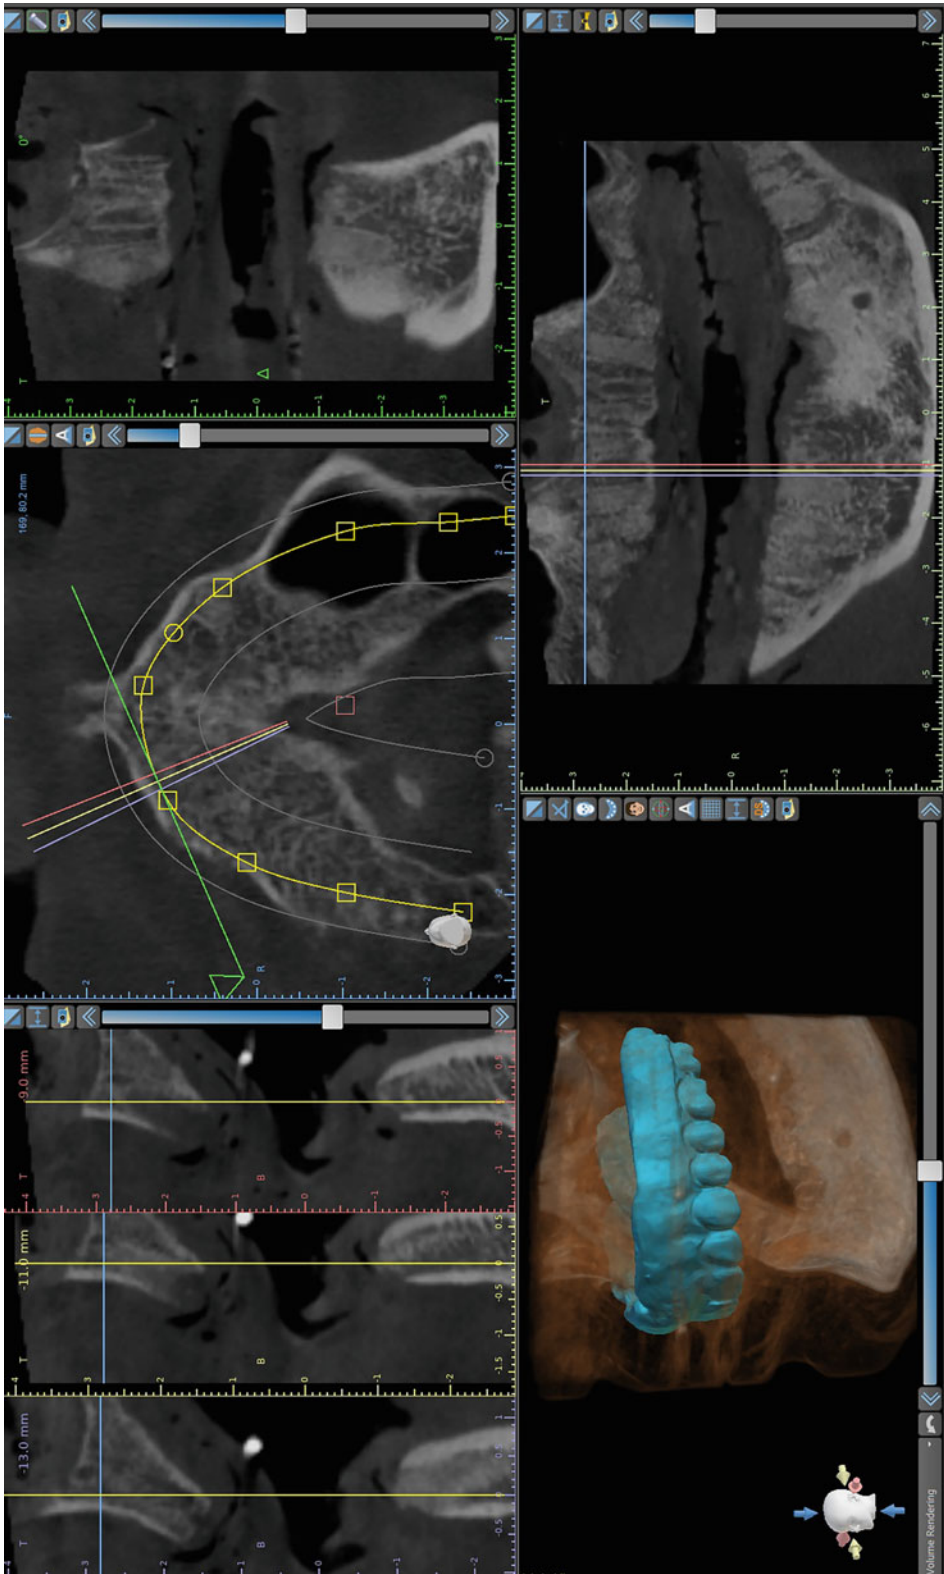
Patient intra-oral scan aligned to patient CBCT for implant planning
